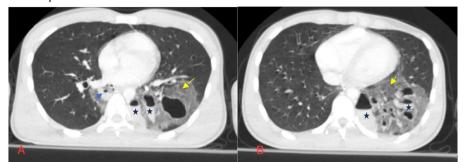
A .	Thora	ax CT a	axial sect	tions; lac	eration	cavit	y in th	ne lowe	er lobe o	of the r	ight lung	(blue	arrow)	Figures	1A-1B	. Lac	eration
